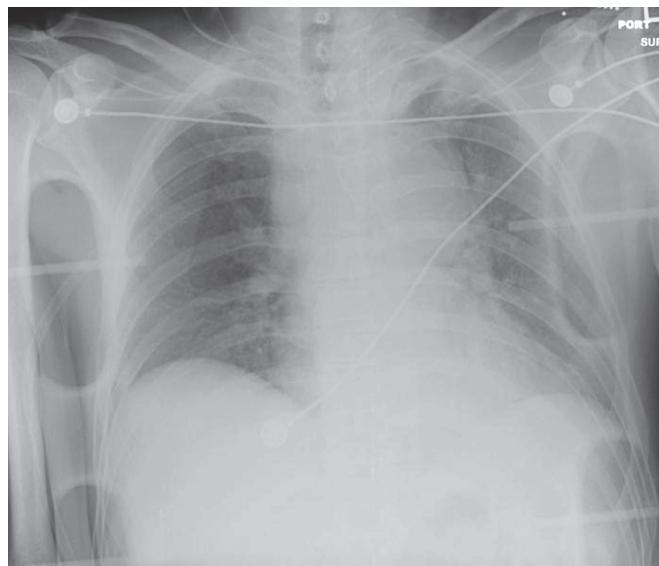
Chest radiograph of a patient with blunt thoracic aortic injury showing a widened mediastinum and obliteration of the aortic knob.
